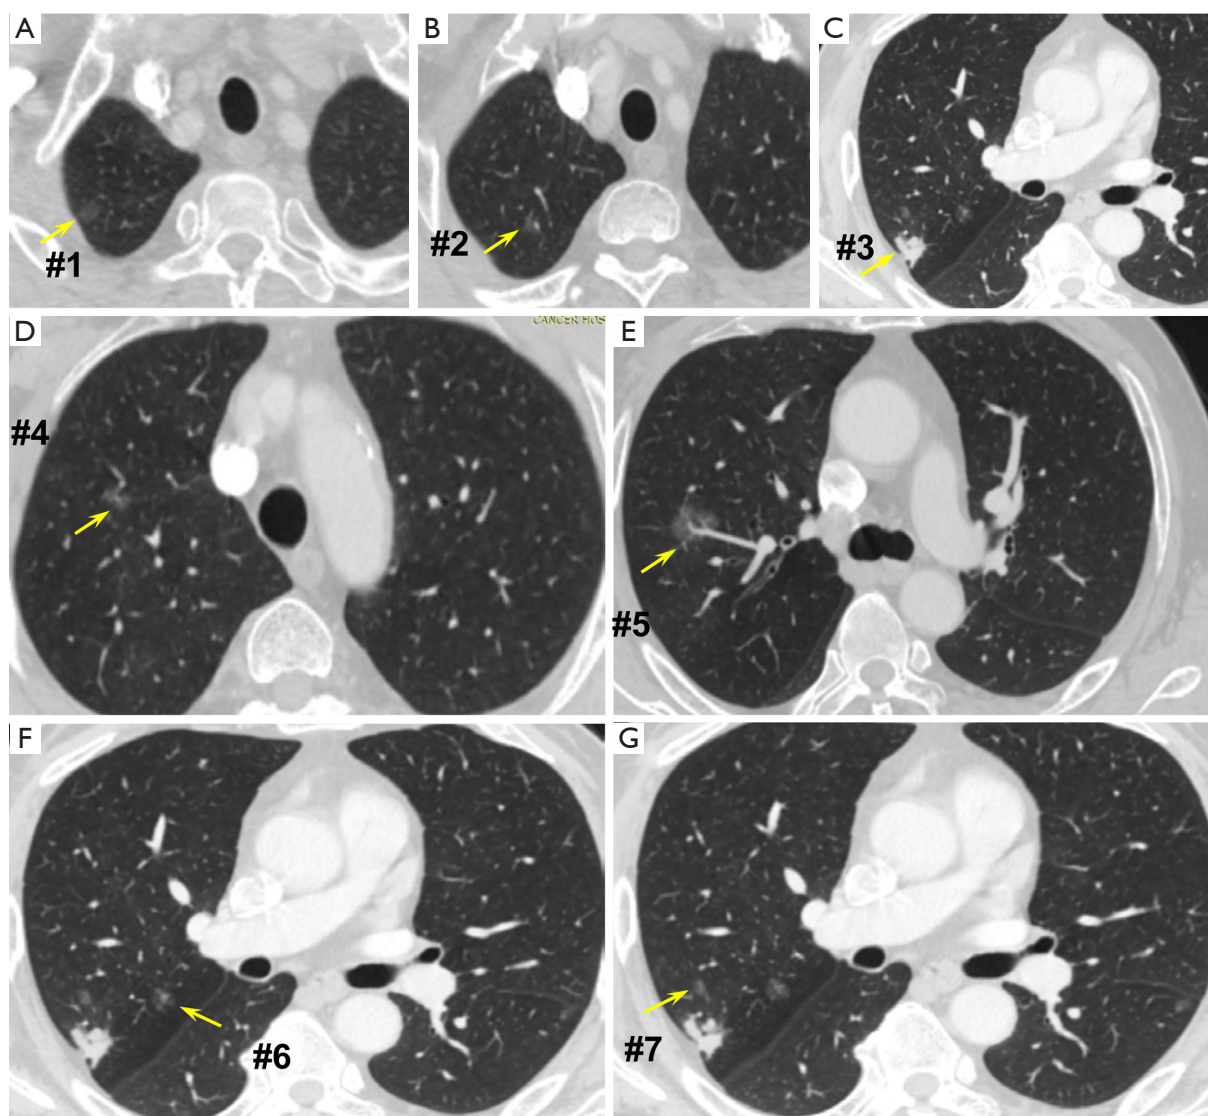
The CT scans of a patient with seven nodules (shown via yellow arrows) in right upper lobe who underwent lobectomy (A-G). Nodule #1 (A), #2 (B), #4 (D), #6 (F) and #7(G) show as pGGN; Nodule #5 (E) shows as PSN; Nodule #3 (C) shows as pure solid nodule.
